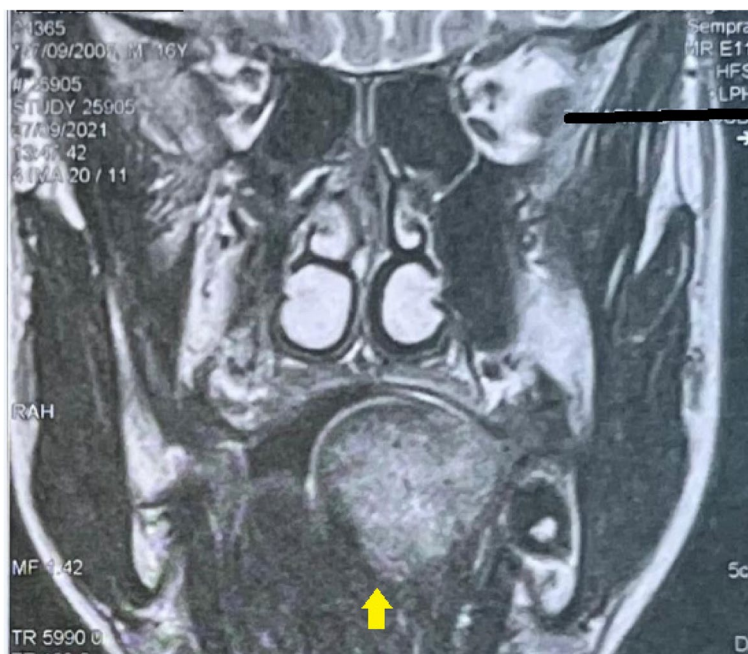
MRI T2 sagittal view showing a well circumscribed hyper-intense tongue base mass (arrow)
